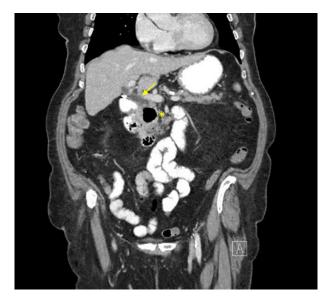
Coronal CT scan: D2 diverticulum and peripancreatic fat infiltration (asterisk).
